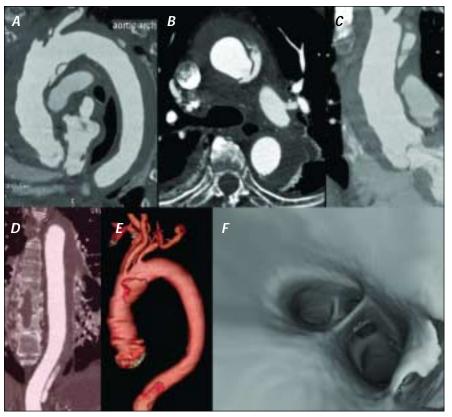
Three-dimensional CT reconstructions showing the location of a dissection, or pseudoaneurysm, just proximal to the origin of the innominate artery.
